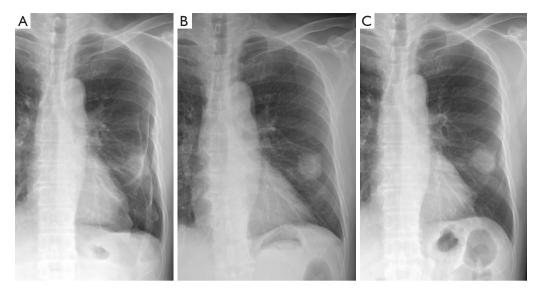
Chest radiographs taken on the Case 3. (A) Before needle aspiration. (B) One hour after needle aspiration. (C) Twelve hours after needle aspiration.
